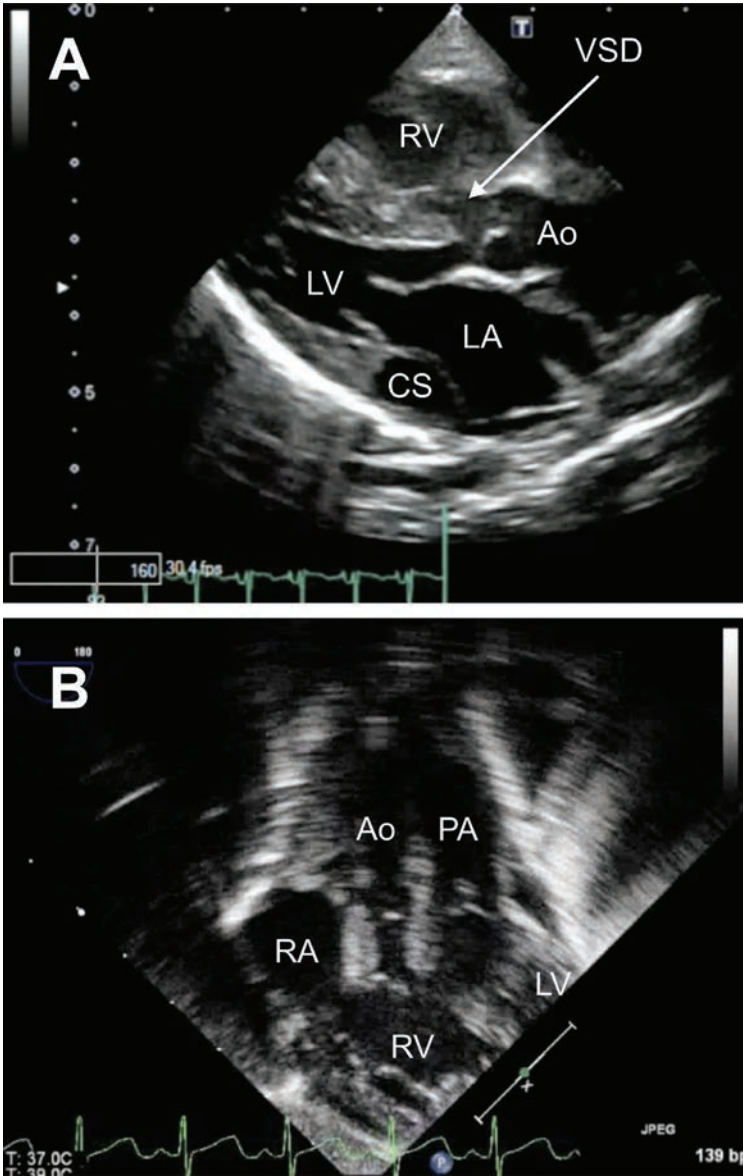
Echocardiographic diagnosis of DORV. A) TTE parasternal long-axis image of a patient with DORV and subaortic VSD showing the position of the aortic root over both ventricles, a VSD, and aortomitral discontinuity related to conal tissue. A dilated coronary sinus (CS) is seen related to a left SVC draining into the CS. The patient also had pulmonary stenosis (not shown). B) TEE deep transgastric image in a patient with DORV and subpulmonary VSD (Taussig-Bing) showing the origin of both great arteries from the RV, bilateral conal tissue, and narrowing of the subaortic region. There was associated aortic arch obstruction.
